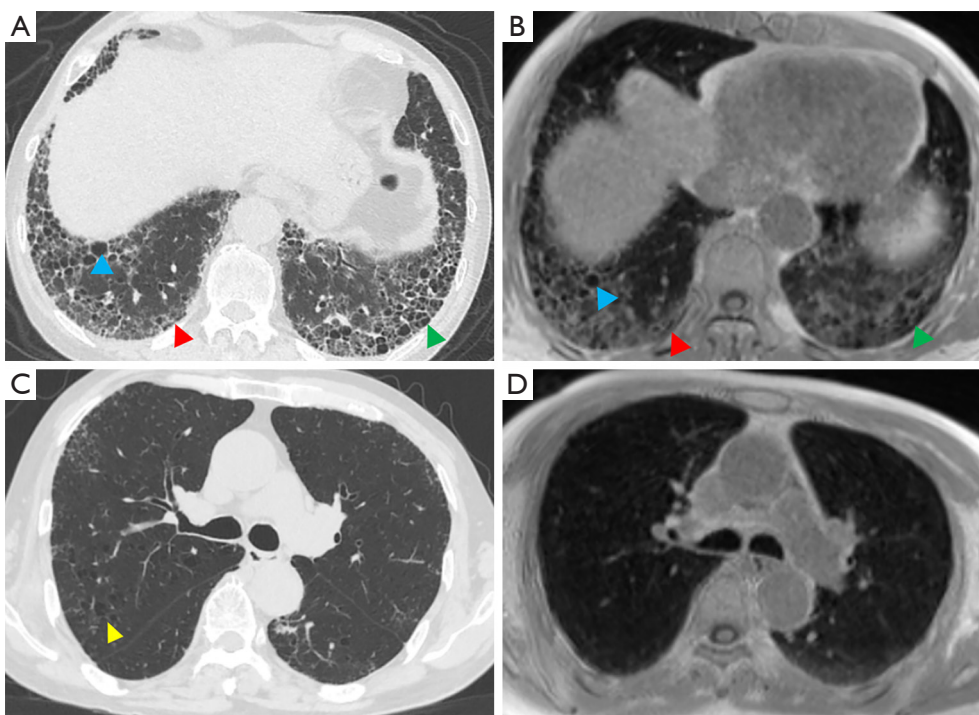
A 68-year-old male patient with interstitial pulmonary fibrosis and emphysema. Images obtained with HRCT (A), and 3D UTE-MRI (B) show honeycombing (green arrow), reticular patterns (red arrow), and traction bronchiectasis (blue arrow) in the left and/or right lower lobes. The image quality of the 3D UTE-MRI (IQS: 4) was lower than that of the HRCT (IQS: 5). The extent of pulmonary fibrosis on images obtained with 3D UTE-MRI (IQS: 10) was lower than those obtained with HRCT (IQS: 14). The images obtained with HRCT also showed that the pulmonary emphysema (yellow arrow) was heterogeneously distributed in the low attenuated areas of both lungs (C). However, pulmonary emphysema was not seen in the lung segments of the 3D UTE-MRI images (D). The transverse 3D UTE-MRI images are MPRs. HRCT, high-resolution computed tomography; 3D UTE-MRI, 3D ultrashort echo time magnetic resonance imaging; IQS, image quality score; MPRs, multiplanar reconstructions.
